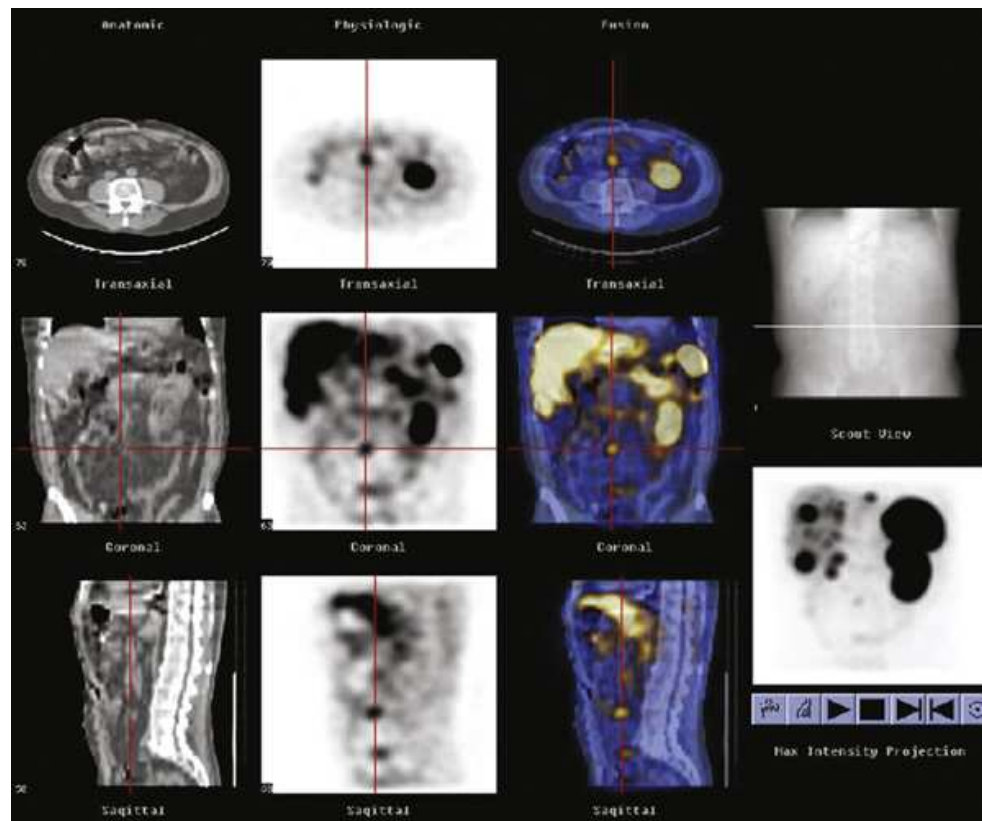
^{111}In -Octreotide SPECT/CT fusion images showing numerous foci of increased uptake within the liver. This is consistent with the patient's known hepatic metastases. Very small focus of increased uptake is also seen in the inferior abdomen, near midline, anterior to the lumbar spine, and is consistent with nodal metastasis. These findings are indicative of somatostatin-avid hepatic and probable nodal metastases.
